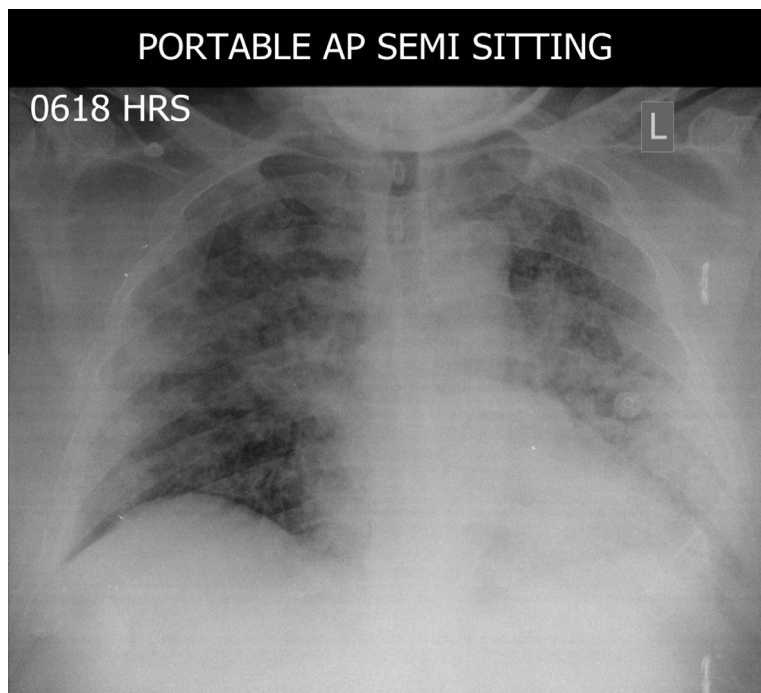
A case of MERS-CoV; Chest X-ray; frontal projection 11 days after admission showing progression with bilateral multifocal opacities.
